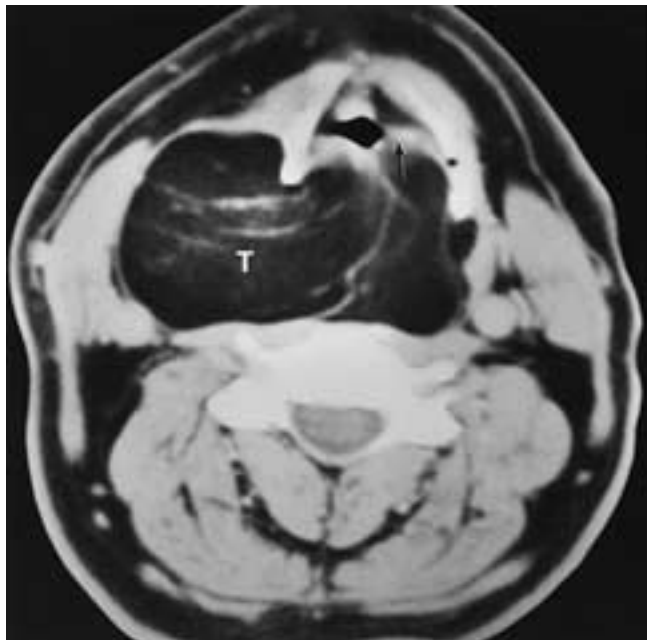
Axial CT shows a lipoma in the soft tissues of the neck and retropharyngeal space. Large tumor extending posterior to the larynx and displacing the larynx anteriorly. Note how the fat appears to bulge into the supraglottic-paraglottic space (*arrow*). The lesion at this level is actually retropharyngeal, with the pharyngeal lumen located between the tumor and the larynx. The anterior wall of the pyriform sinus is being pushed anteriorly, compressing the paraglottic fat but not invading. *T*, Tumor.
